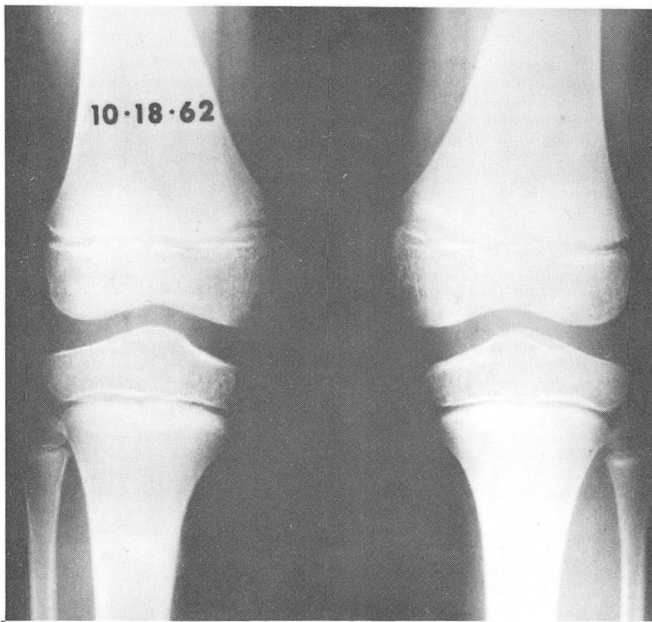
Case 2. Progress roentgenogram taken on October 18, 1962, showing the healed fracture and callus.
